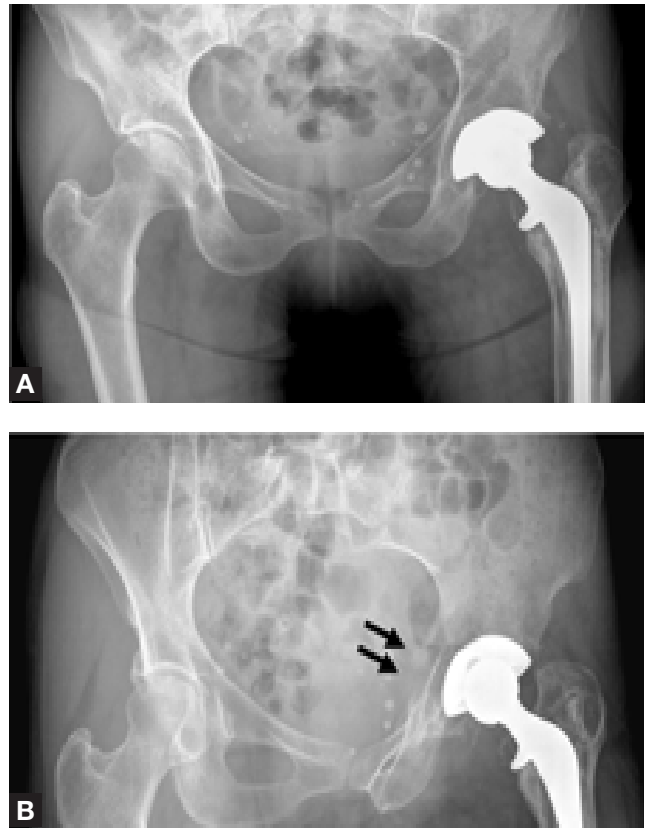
(A) Anteroposterior x-ray of pelvis shows periacetabular osteolysis medially. Extensive osteolysis is also seen around the cemented femoral prosthesis. (B) Left posterior oblique x-ray shows osteolysis involving the posteromedial acetabulum, with discontinuity of the medial pelvic wall (arrows).
